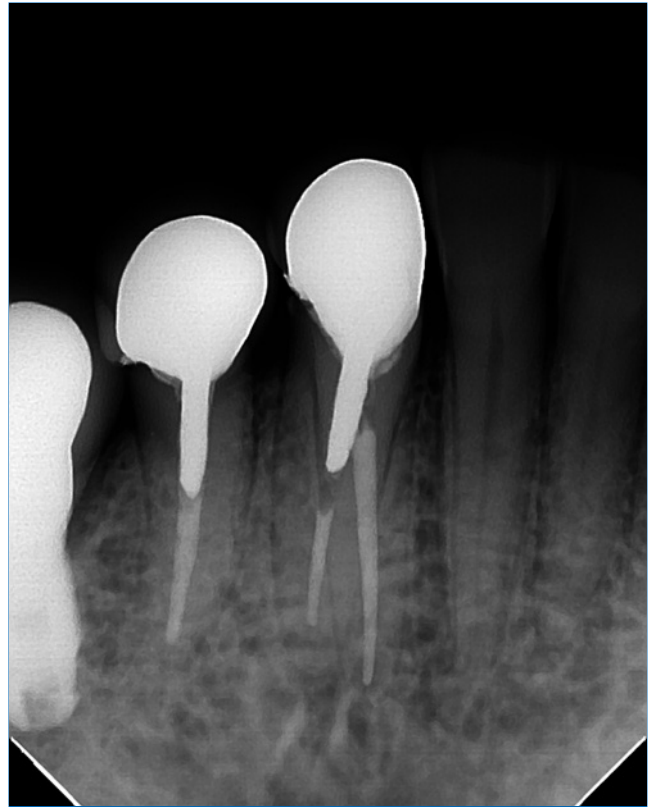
18-month follow-up radiograph showing periapical tissue normality.
